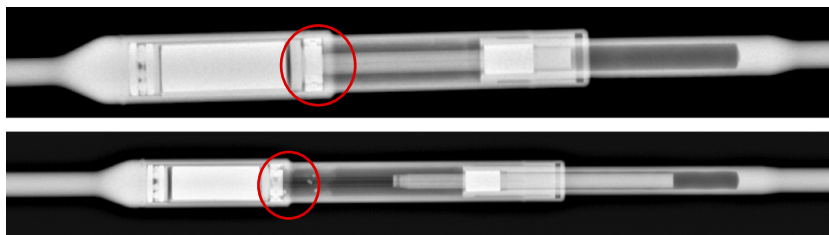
Example of the visualization of the internal mechanism, using high-energy x-ray imaging. On top, A construct with intact pin, found functional at retrieval. On the bottom, An implant showing clear pin fracture and a separation of the internal screw from the magnet area.
